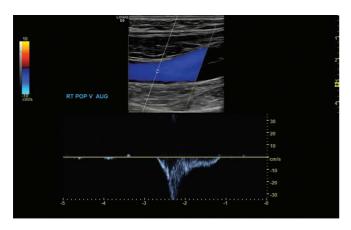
Popliteal vein augmentation visualized with spectral Doppler.
